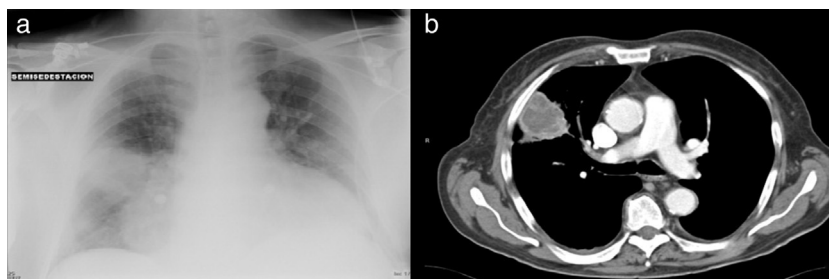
Chest radiograph (a) and chest CT scan (b) right parahilar mass.
